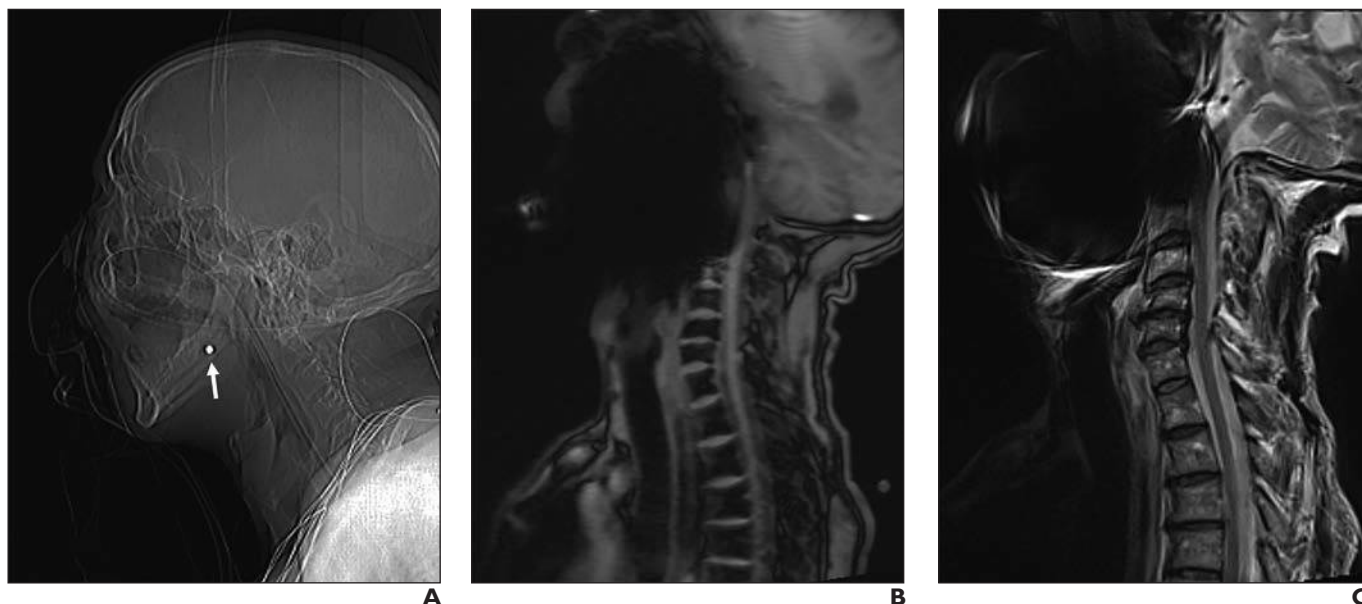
63-year-old woman with facial injury from BB bullet. A, Scout CT image shows BB (arrow) embedded in facial soft tissues. B and C, Sagittal scout (B) and T2-weighted (C) MR images show metallic artifact from BB extending throughout face and upper cervical spine.
